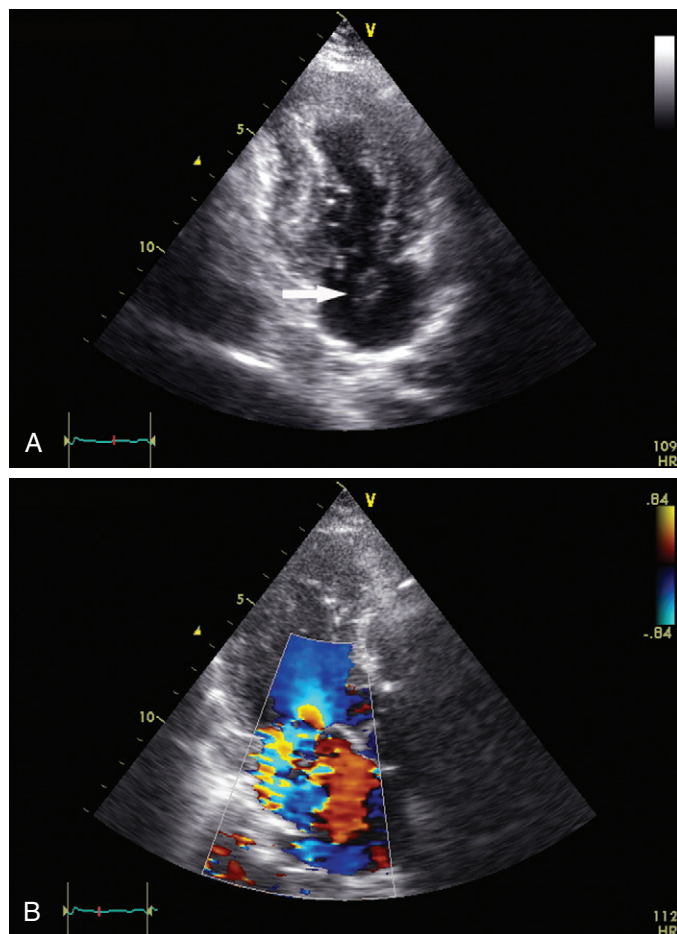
Transthoracic echocardiography in a patient in cardiogenic shock 24 hours after an anterior non-ST-segment elevation myocardial infarction (NSTEMI). A, Apical two-chamber view shows rupture of the anterolateral papillary muscle, which moved freely into the left atrium (arrow). B, Apical long-axis view shows severe mitral regurgitation in the same patient.
